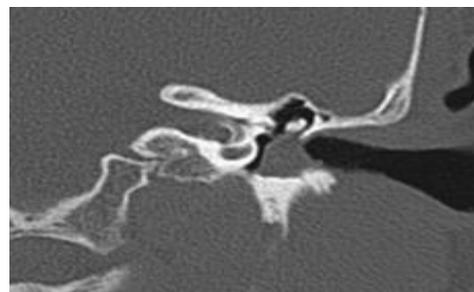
Coronal CT scan of the left temporal showed a soft tissue mass (*keratosi obturans*) in the fundus of external auditory canal and producing several indentations at the base of canal
